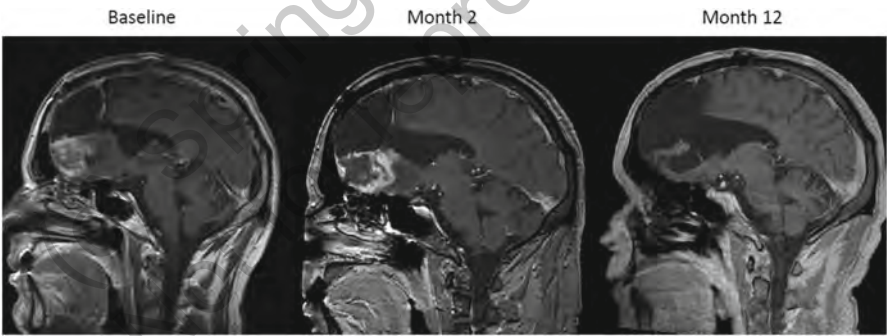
T1-weighted post-contrast MR images of a 48-year-old man with prior grade II astrocytoma, which transformed to GBM as confirmed by tissue biopsy. The subject progressed after receiving radiotherapy with concomitant temozolomide followed by 3 cycles of adjuvant temozolomide. He subsequently responded to TTFields, achieved at 12 months, and remained stable for an additional 20 months while on treatment. Vymazal et al. Response patterns of recurrent glioblastomas treated with tumor-treating fields. *Semin Oncol.* 41 Suppl 6:S14-S24, 2014. Elsevier
